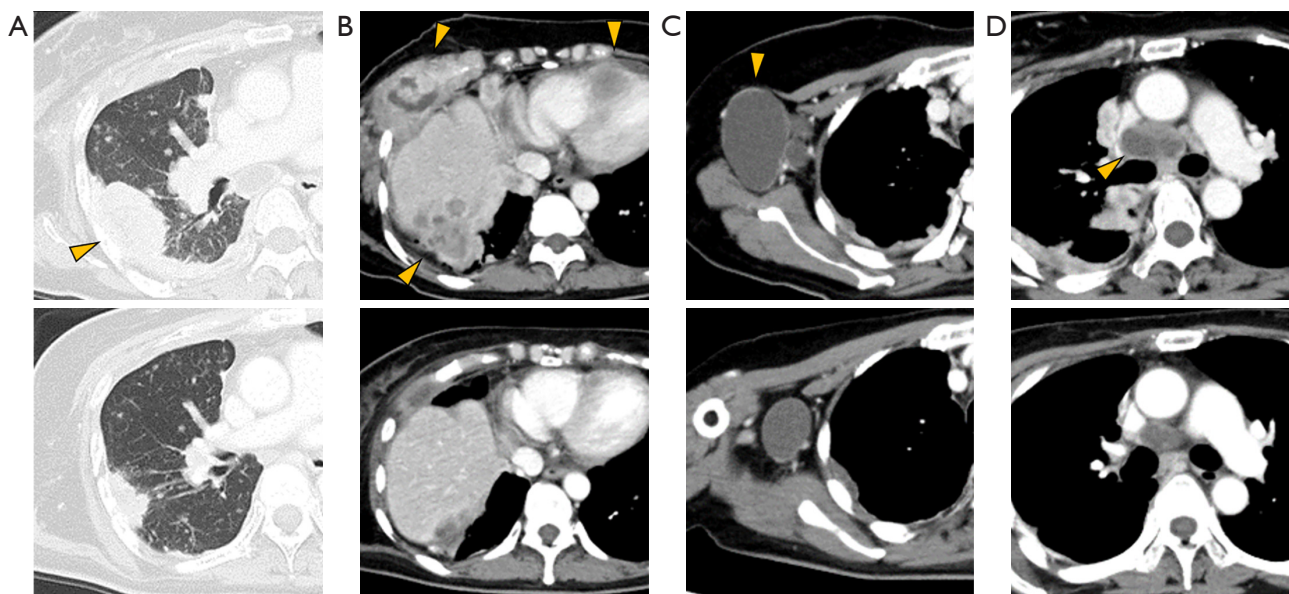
Results of computed tomography (upper row) before treatment with drugs and (lower row) 13 weeks after lenvatinib and selpercatinib treatment began. Arrows indicate metastatic lesions of the lung (A), chest wall, liver, and heart (B), and as well as the lymph nodes in the right axilla (C) and the mediastinum (D).
